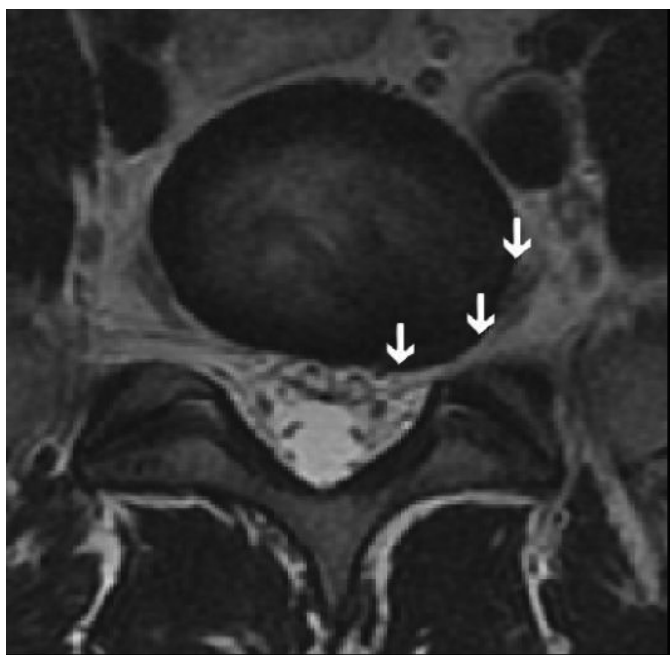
Axial MRI image. Left-side foraminal protrusion of the disc L5-S1 (arrows).
